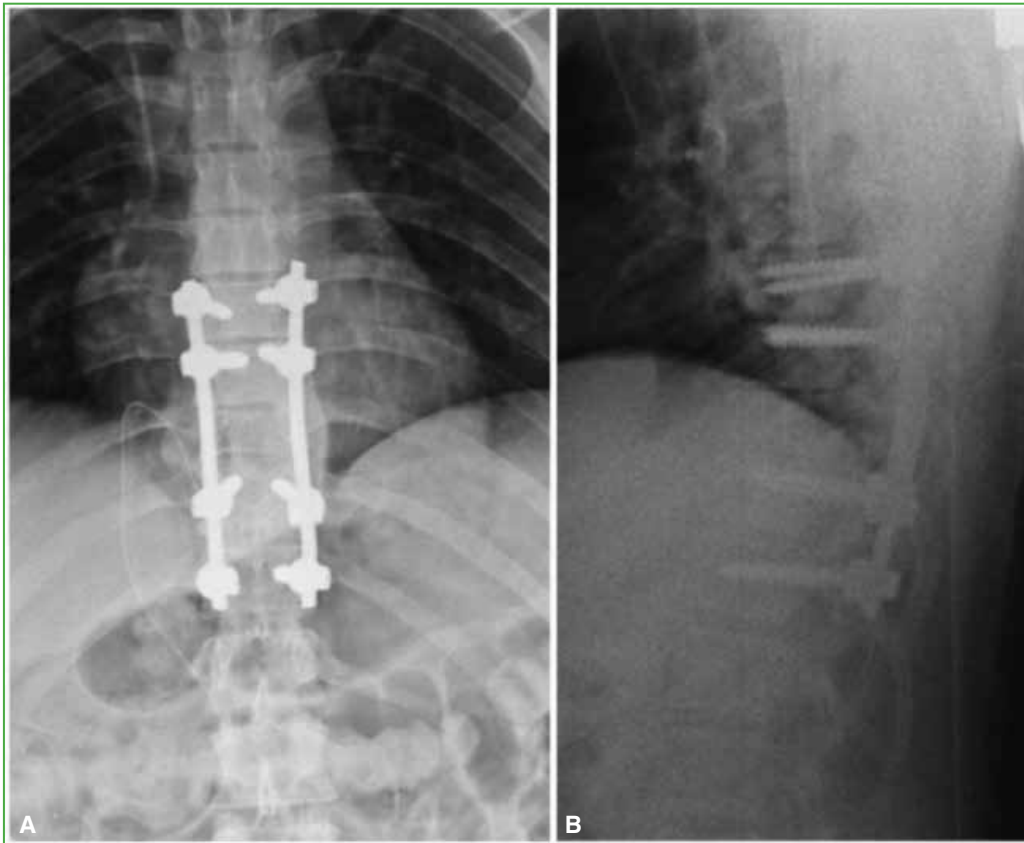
Case 1. A 22-year-old man. Postoperative anteroposterior (A) and lateral (B) radiographs of the thoracic spine. Pedicle screw fixation from T7 to T11 is visualized.
